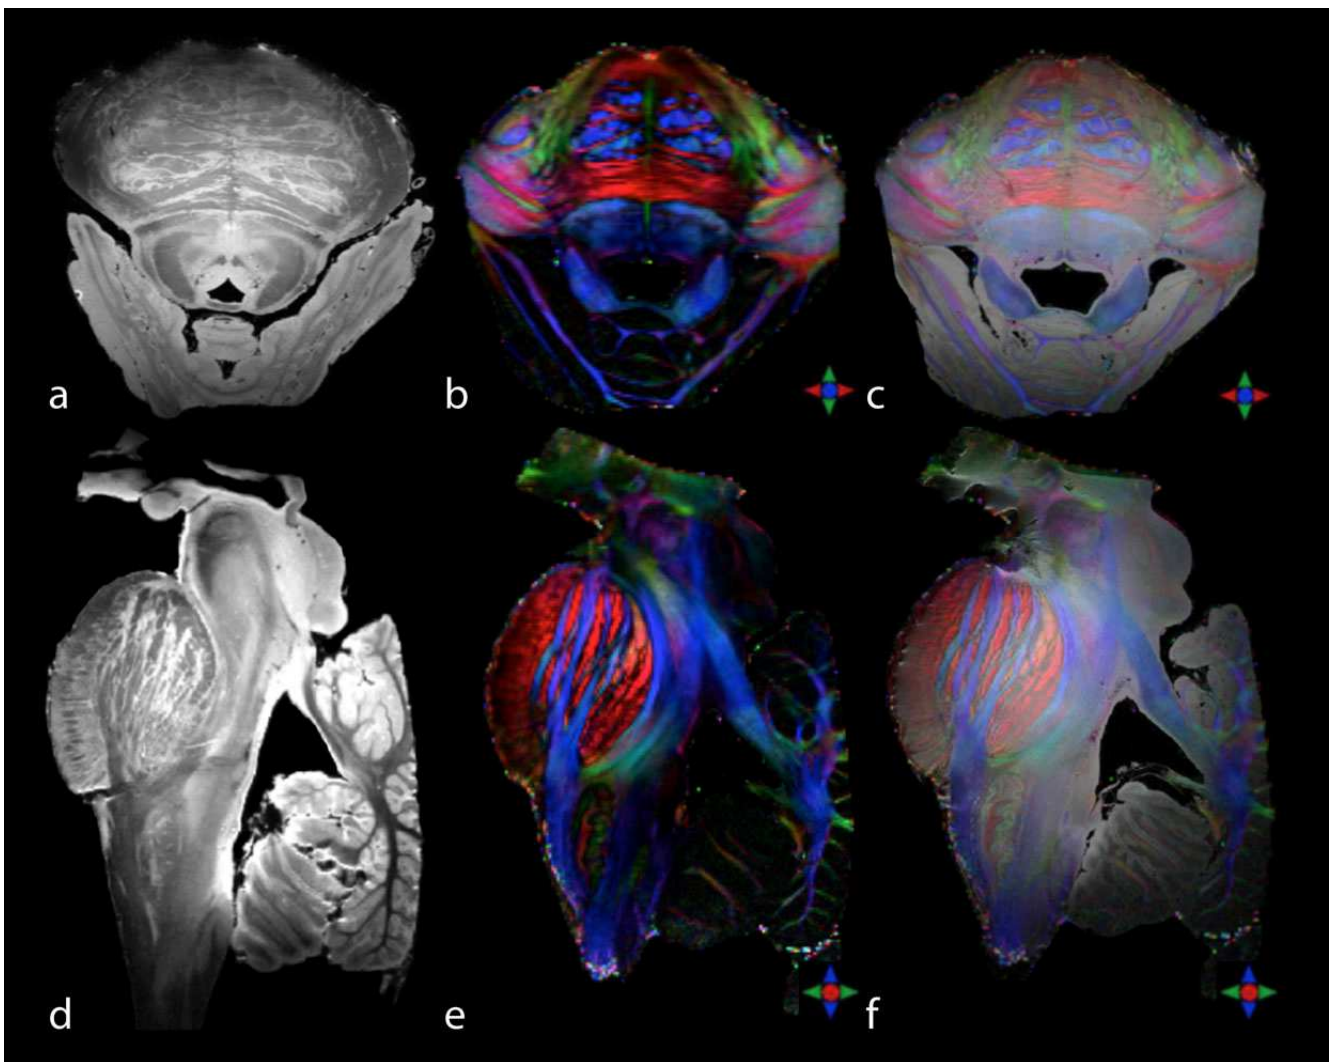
Acquisitions of the brainstem with the Bruker 11.7T preclinical MRI system.
